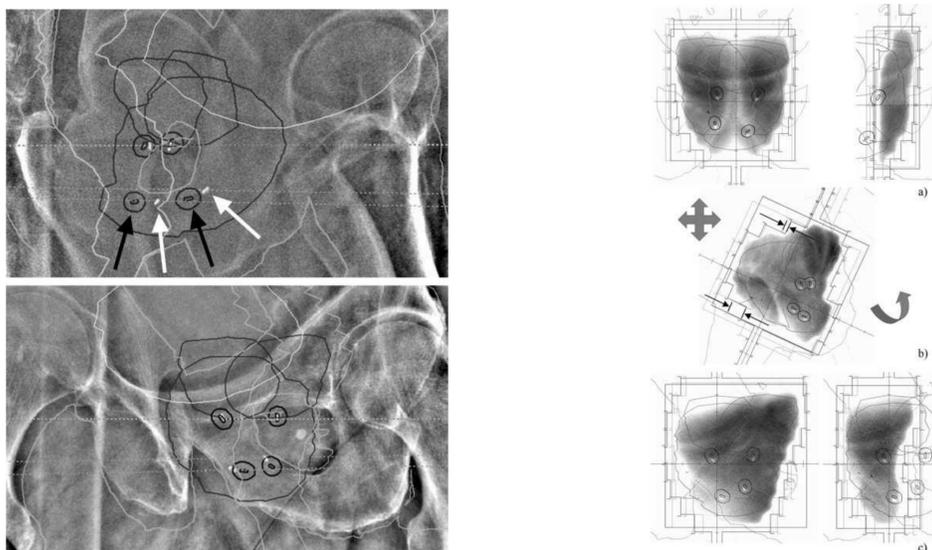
Left: Pre-treatment kV radiographs from two orthogonal views. Initially planned (untransformed) position of bony anatomy, markers and PTVs (prostate, SVs) are automatically overlaid to visualize inter-fractional changes before registration. Right: Correction of rotations and translations: 15 MV portal images of a sample of IMRT segments from different gantry angles: a) 0°, b) 103°, c) 254°. Initially planned beam aperture (leave positions in light grey) and real-time adapted field (bold) are blended in. Smaller discrepancies between gold marker projections of patient at actual fraction and augmentation of accordingly transformed structures from planning CT indicate intra-fractional movements.
